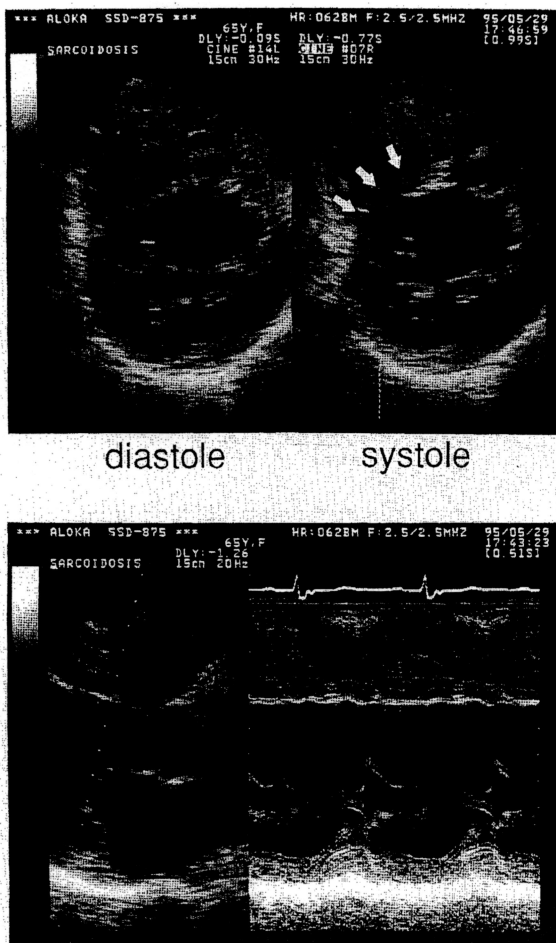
Cross-sectional echocardiographic images. Top: Short-axis view at the level of the mitral valve. Bottom: Parasternal long-axis view and M mode view at the level of the mitral valve. Note that the anterior basal portion of the interventricular septum was thin and dyskinesic (white arrows).
